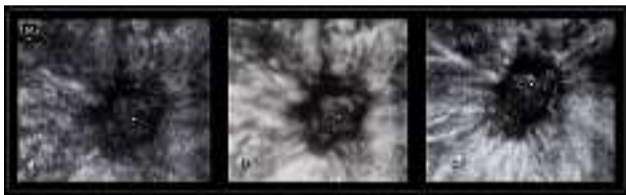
Coronal plane (C plane) of an invasive ductal breast cancer with retraction pattern sign, a: Conventional C plane, b: Static VCI 1 mm slice with surface smooth and X-ray mode rendering, c: Static VCI 1 mm slice with surface mode rendering
